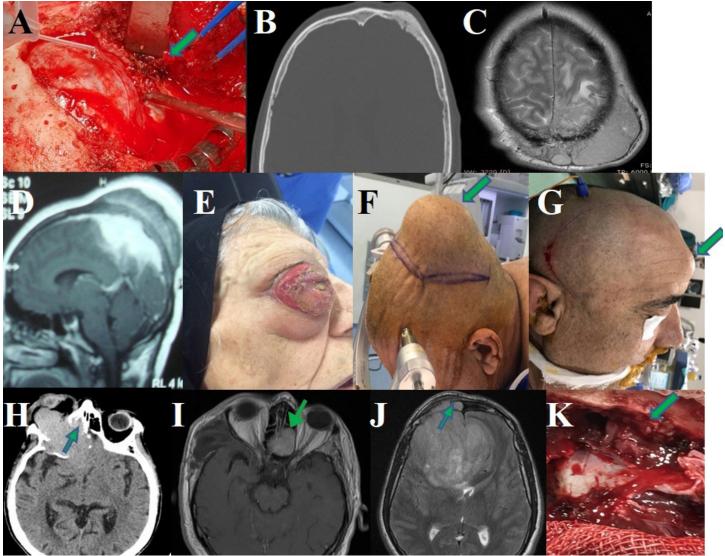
(A) Surgical view of extracranial invasion. (B) Imaging of hyperostosis on computed tomography. (D andE) Cranial MR section showing the extracranial portion of the tumor that is larger than the intracranial portion. (E–G) Facial disfigurement or asymmetrical growth of the skull. (H–K) Extracranial growth along the paranasal sinuses
